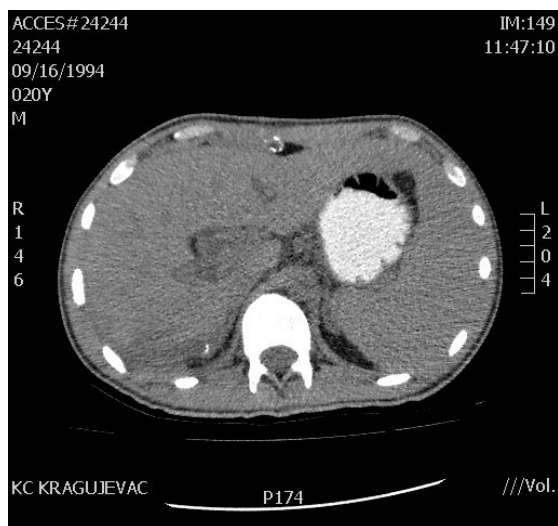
Computed tomography scan image of the liver on the 23rd day after removing liver packs with no signs of active bleeding.
